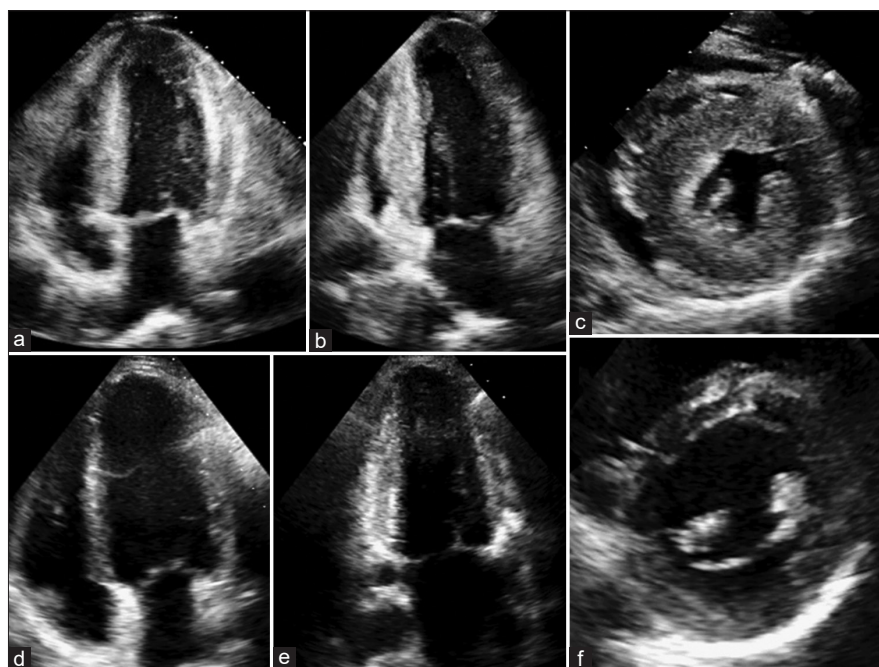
Transthoracic echocardiogram. At admission, apical four-chamber (Panel a), two-chamber (Panel b), and parasternal short-axis (Panel c) views showed left ventricular (LV) hypertrophy (maximal LV wall thickness 19 mm), systolic dysfunction (LV ejection fraction [LVEF] 36%), and pericardial effusion. Seven days after treatment with methylprednisolone, LV wall thickness (10 mm) and LVEF (60%) were normal, and there was resolution of pericardial effusion (Panels d-f)
